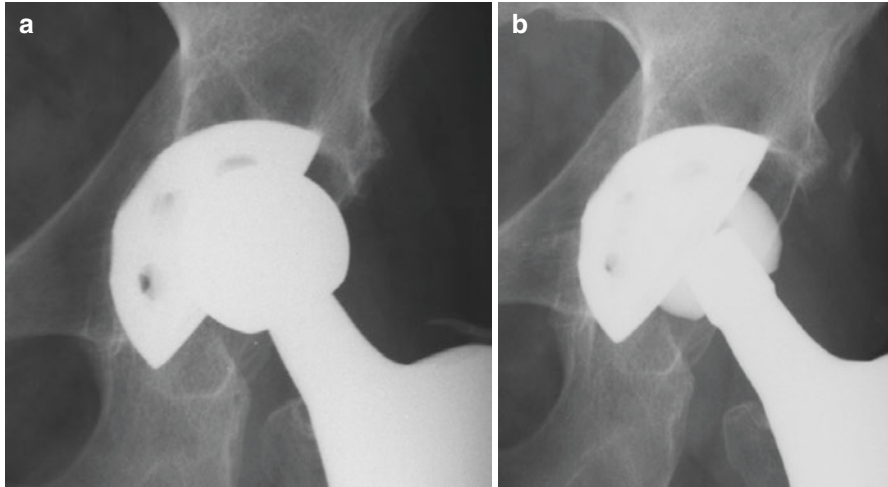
(a) Anteroposterior radiograph of hip a shows a radiographically stable cementless cup and replaceable polyethylene. (b) Osteolytic lesions were debrided and grafted and a new polyethylene liner was inserted with a ceramic femoral head
